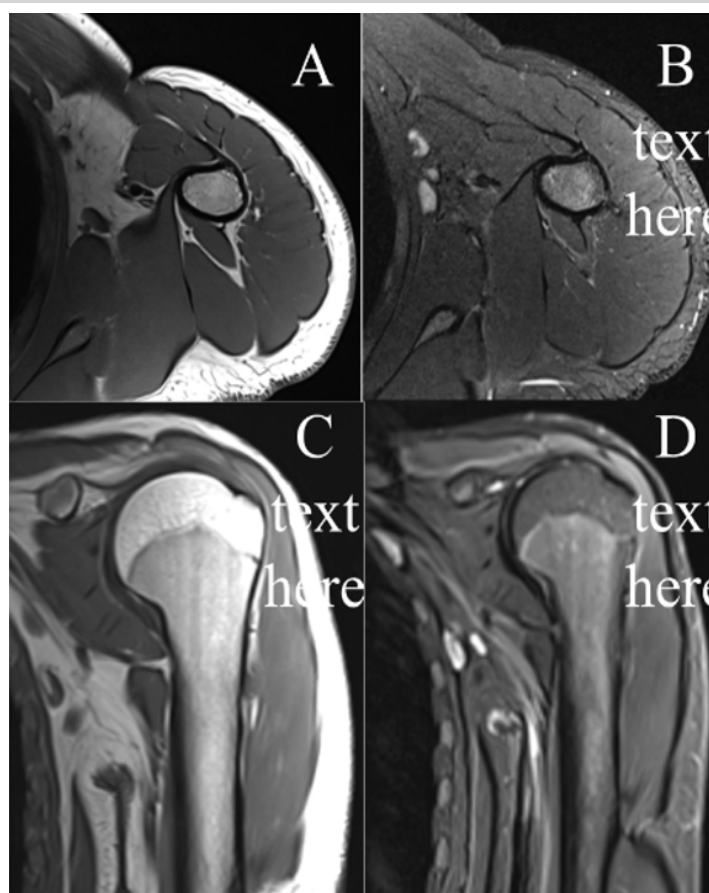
Magnetic resonance imaging of the left proximal humerus. (a and b) T1- and T2- weighted fat-sat axial cuts showing the almost complete resorption of the osteochondroma with only a bony remnant at the posterolateral aspect of the proximal third of the humerus. (c and d): T1 and T2 fat-sat coronal cuts showing almost complete resorption of the lesion.
